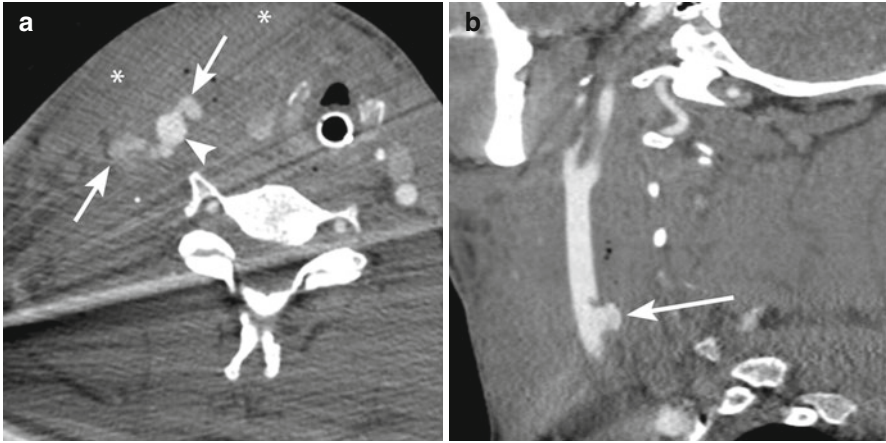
Axial (a) and sagittal (b) images from a computed tomography angiogram (CTA) of a patient with a gunshot wound to the right neck. There is injury to the anterior and posterior aspects of the right common carotid artery (*arrowhead*) with active extravasation of contrast (*arrows*) consistent with active bleeding and associated large hematoma (*asterisks*). Note small amounts of streak artifact from bullet fragments
